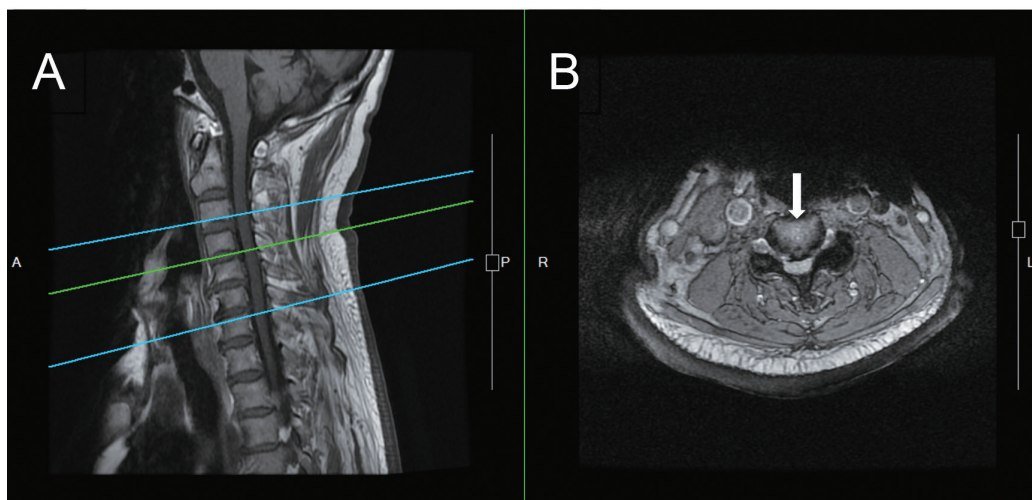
MRI of cervical spines. On Figure 1A, green line indicated the level was between C4 and C5. On Figure 1B, cerebrospinal-fluid space was obscured (white arrow), which suggested compression of thecal sac. There was no compression of cord because the shape of cord still appeared ovoid.
